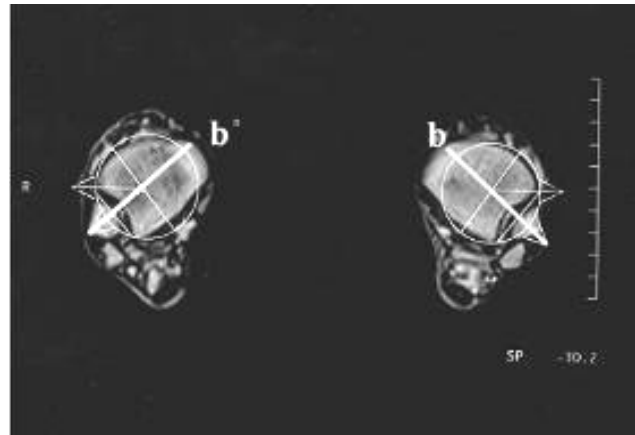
Distal reference line determination for MRI measurement method (line b)
